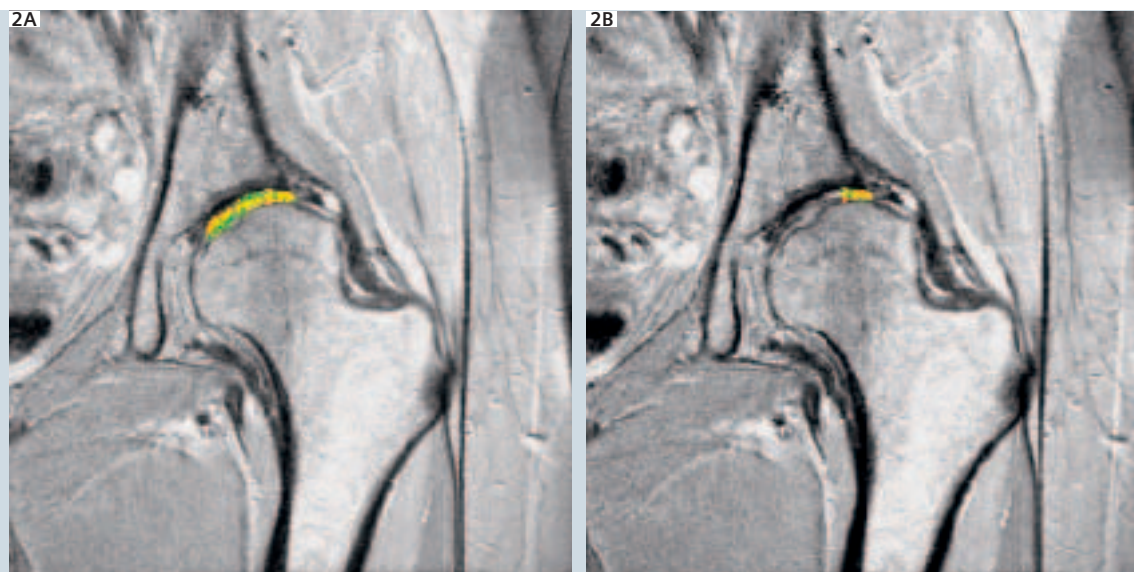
A, B: T1 dGEMRIC of the hip. Color-coded T1-map of a left hip. 26-year-old patient with hip dysplasia. Yellow color indicating a lower dGEMRIC index and therefore a cartilage degeneration. This corresponds in this case with osteoarthritic changes in the X-ray images (Tönnis Grade 1–2).
